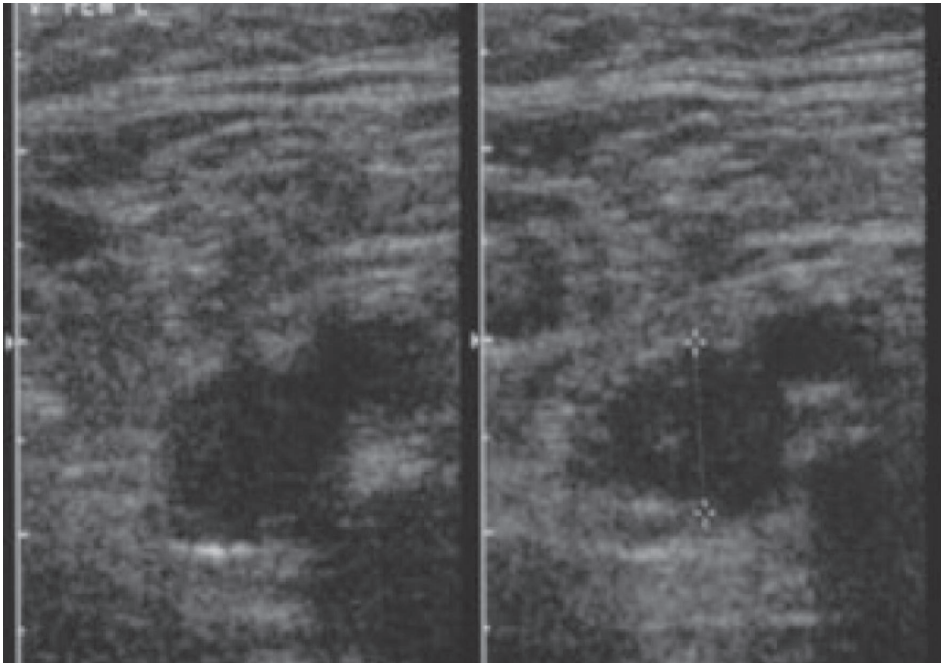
Compression ultrasonography showing deep vein thrombosis in the left femoral vein. Left image without compression, right image with incomplete compression of the femoral vein. Male, 58 years, presented with swelling, discoloration and pain of the left leg. Complaints were present for 1 week
